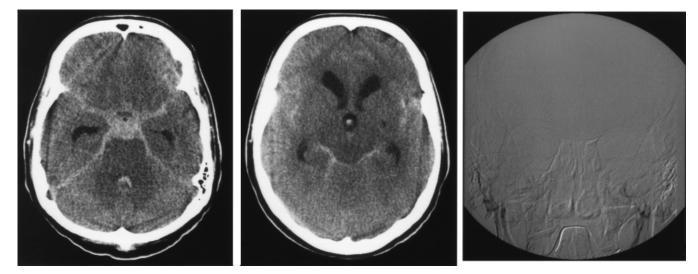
A patient with SAH who was comatose from the outset. CT shows subarachnoid blood, but no other abnormalities. Angiography performed a few hours later proved absence of intracranial circulation.
